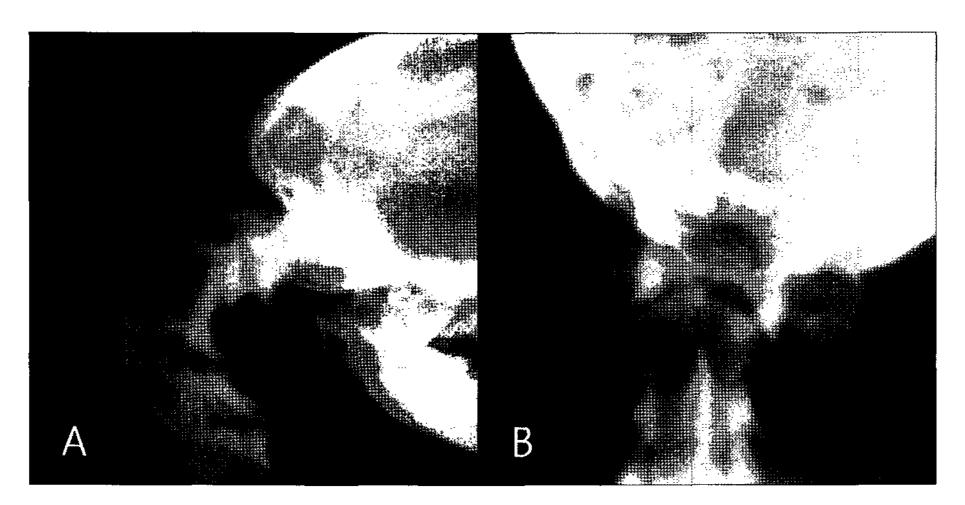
Radiographies of cervical region of the patient. (A) Lateral radiographs showing a marked increase in the gap between the dorsal arch of C1 and the spinous process of C2 when the neck is flexed. (B) Ventrodorsal radiographs showing subluxation of the AA joint.
